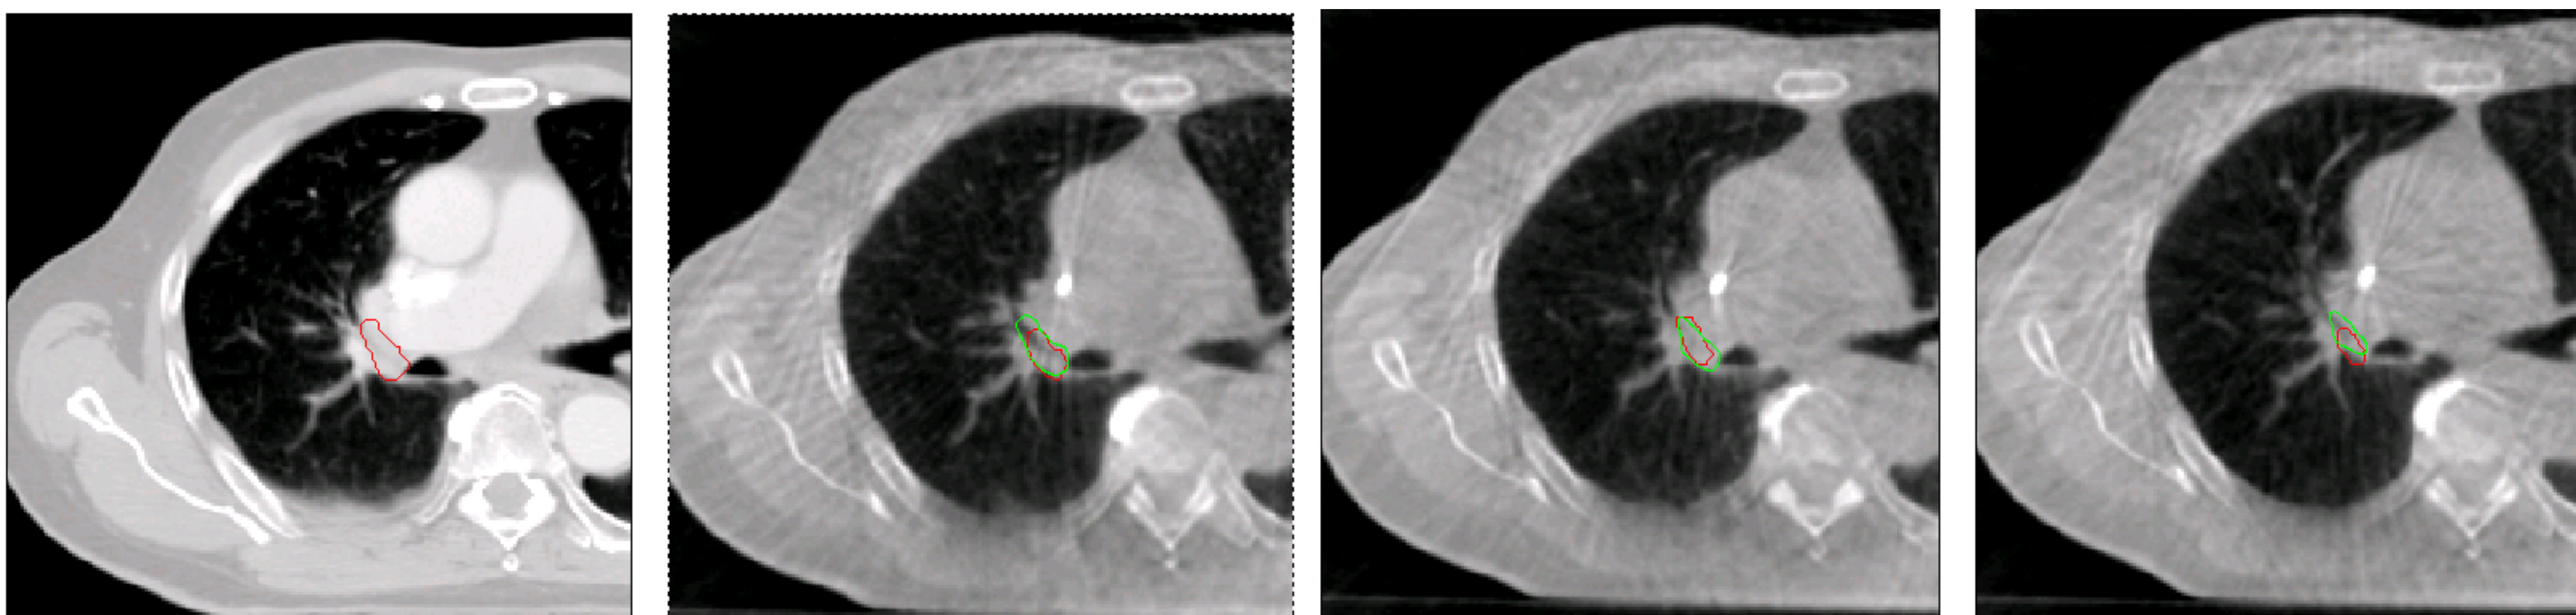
The contouring for one patient is shown, including the planning CT and CBCT from three timepoints in treatment. The manual contours are shown in red and the automatic contour in green. The overlap in contours can be seen, although there is some disagreement. The relative decrease in tumour volume, compared to day one of treatment is also included. It can be seen that the manual contouring showed a greater reduction in volume than the automatic contouring.
